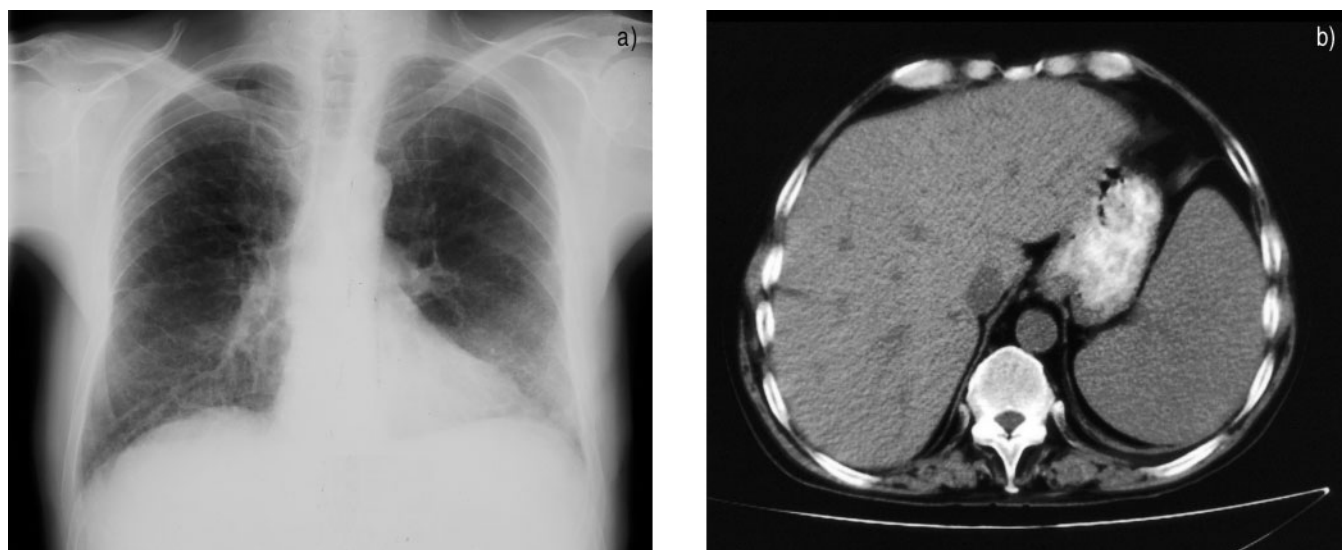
a) Chest roentgenogram and b) computed tomography, of the upper abdomen.
